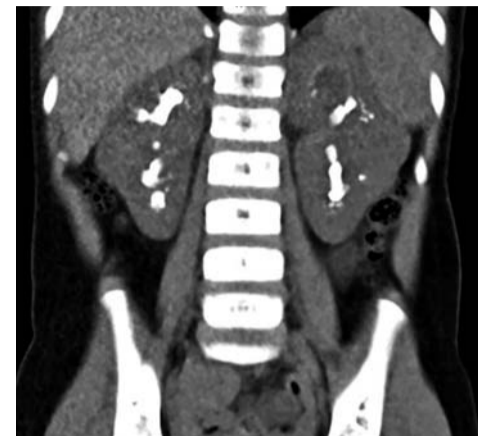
CT of a 3-year-old female with oxaluria and bilateral renal staghorn calculi, for PCNL
